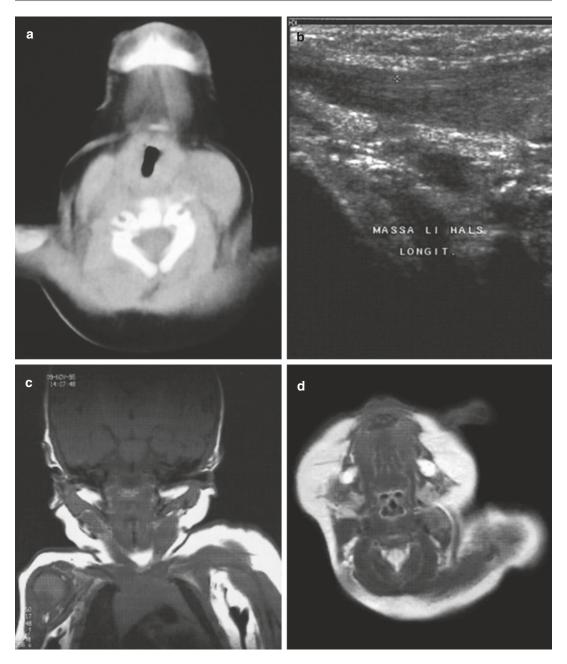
(a–d) Fibromatosis colli in a l-day-old boy (a) and a 7-week-old girl (b–d) presenting clinically with torticollis. (a) CT scan. (b) Ultrasound of the left sternocleidomastoid muscle. (c) Coronal spin-echo T1-weighted MR image. (d) Axial turbo spin-echo T2-weighted MR image. CT scan showing overall enlargement of the left sternocleidomastoid muscle, without obvious change in attenuation (a). On ultrasound scans, there is a fusiform
